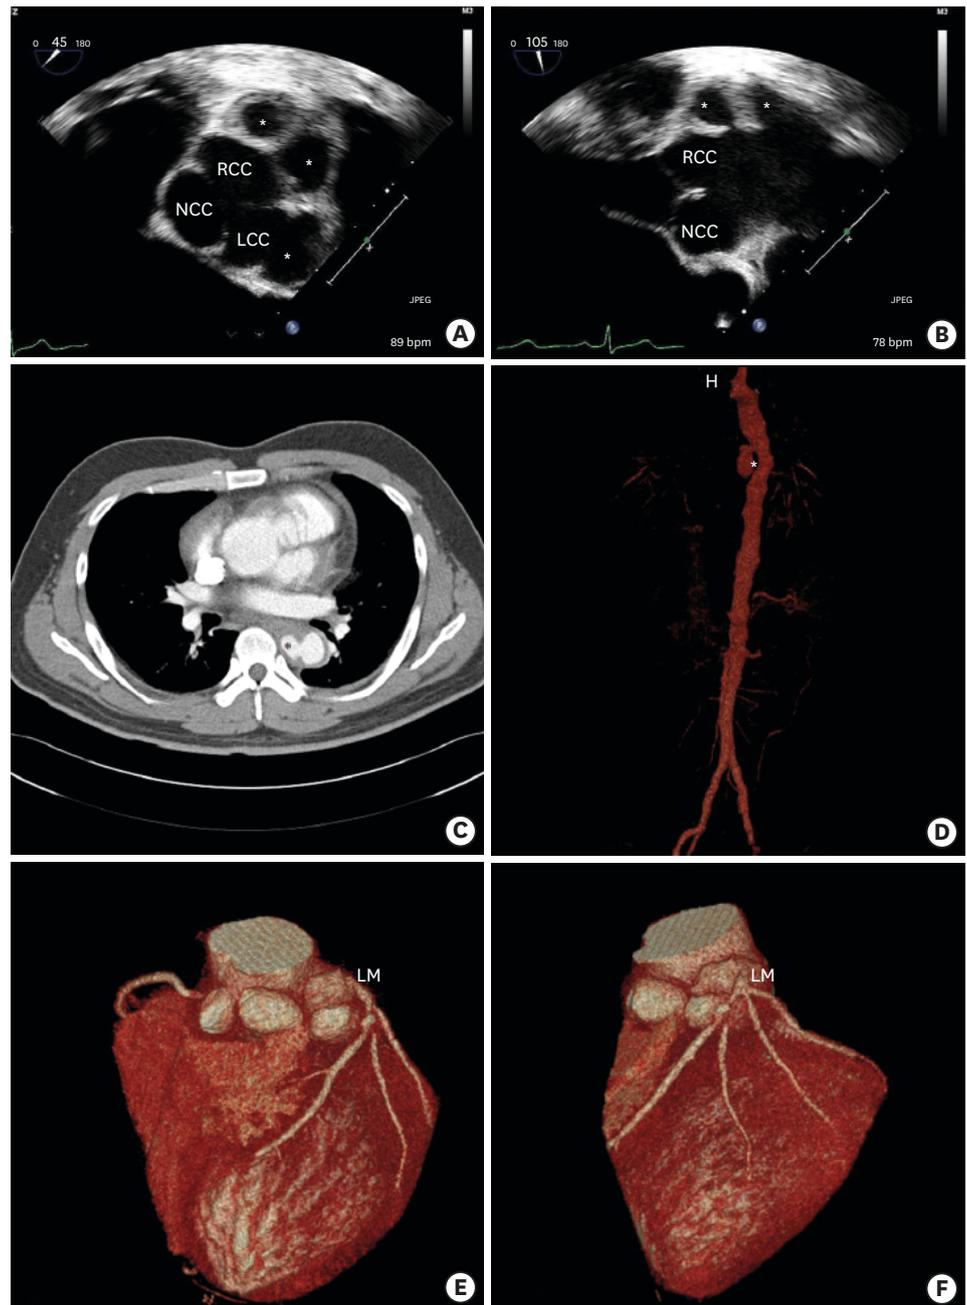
(A) Transesophageal echocardiography revealed that the outpouching structure with mural thrombus arose from the left coronary sinus of Valsalva. (A and B) Distal to the right coronary ostium, the aorta formed another 2 outpouching structures. (C and D) CT revealed another outpouching structure at descending aorta. (E and F) Cardiac multi-detector CT revealed that the left coronary ostium was originated from the aneurysmal wall. CT = computed tomography; LCC = left coronary cusp; LM = left main artery; NCC = non-coronary cusp; RCC = right coronary cusp. *Aneurysm.
